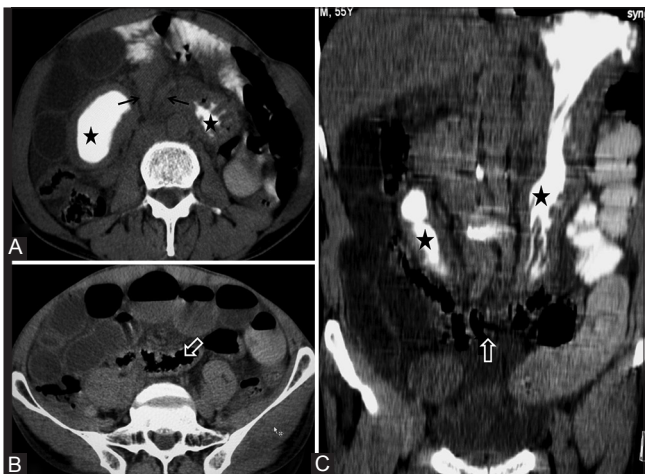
(A-C): CT scan axial and oblique coronal images show elongated and stretched down stomach (star-shaped markers) and transverse colon (white open arrow) with two collapsed small bowel loops with beaking (black arrows in A) seen antero-superior to the antral part of the stomach. Dilated small bowel loops are seen right lateral and inferior to the stomach and the transverse colon. Mild free fluid in between the bowel loops and mild distal stomach wall thickening (congestive edema) are also noted
